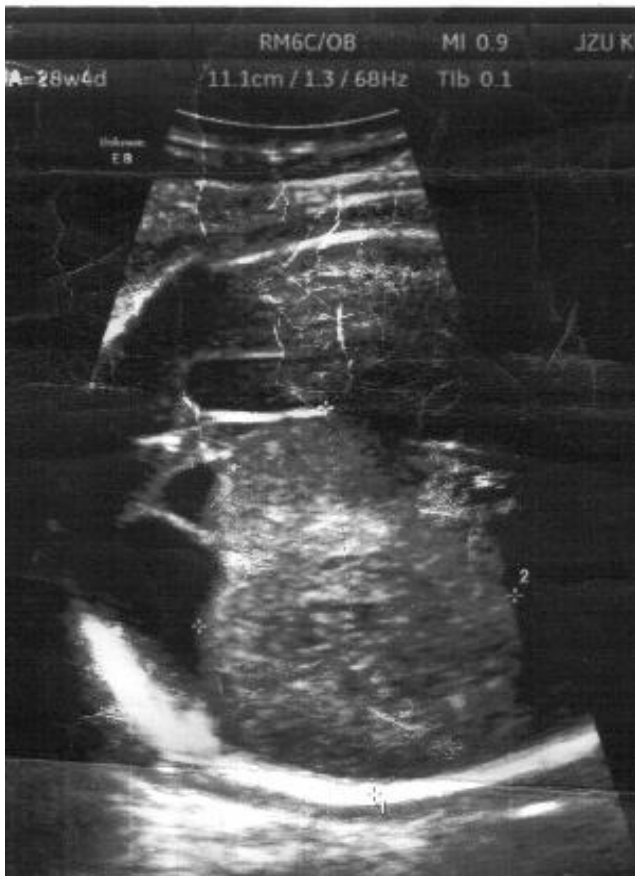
Ultrasound 2-D image of the fetal head
